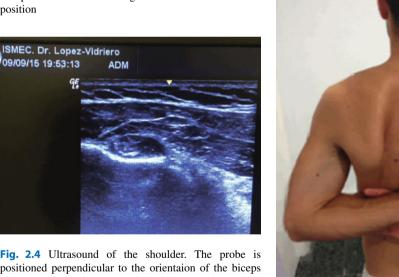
Ultrasound of the shoulder. The probe is positioned perpendicular to the orientaion of the biceps sulcus. A black circle around the biceps tendon, called "Halo-phenomenon" typical for biceps tendinitis
